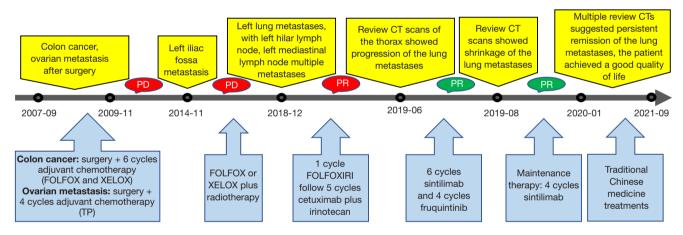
Flow of diagnosis and treatment. CT, computed tomography; PD, progressive disease; PR, partial response; TP, Taxol (paclitaxel)-Platinum (cisplatin/carboplatin) regimen.
